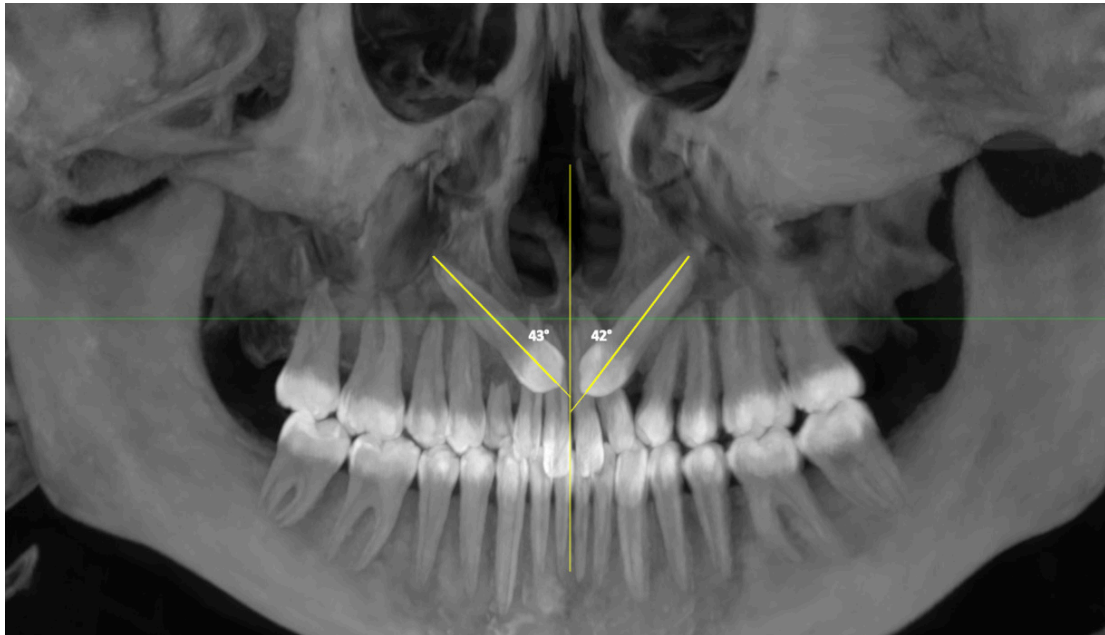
Orthopantomogram radiography pre-treatment.
